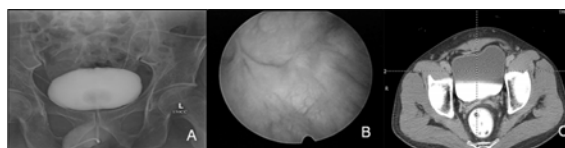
Post-operative follow-up Cystogram at day10 showing no leakage of contrast media; A), Cystoscopy 1st and 3rd months after surgery; B), CT scan whole abdomen at 2 years post-operatively; C).
